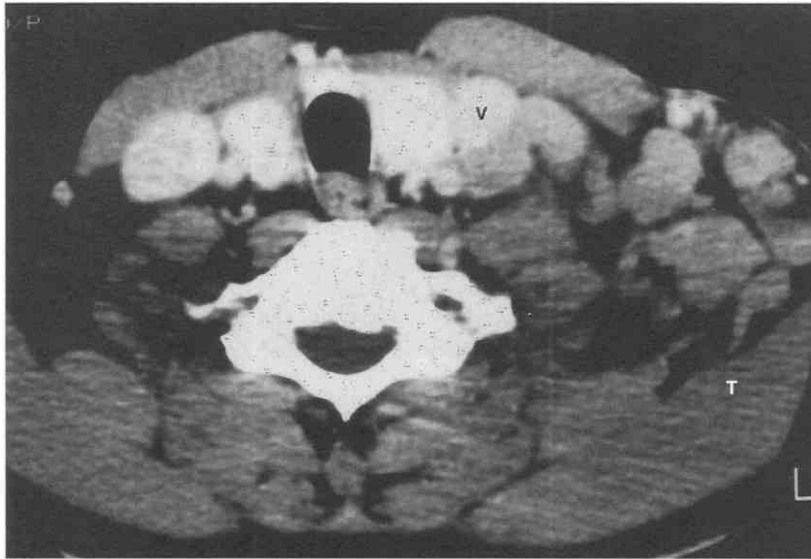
Hodgkin's disease. Axial contrast-enhanced CT scan at the level of the first tracheal ring demonstrates multiple enlarged homogeneous lymph nodes filling the left posterior triangle. Lymph nodes adjacent to the internal jugular vein (V) are level IV nodes. Lymph nodes adjacent to the trapezius muscle (T) are level V nodes.
